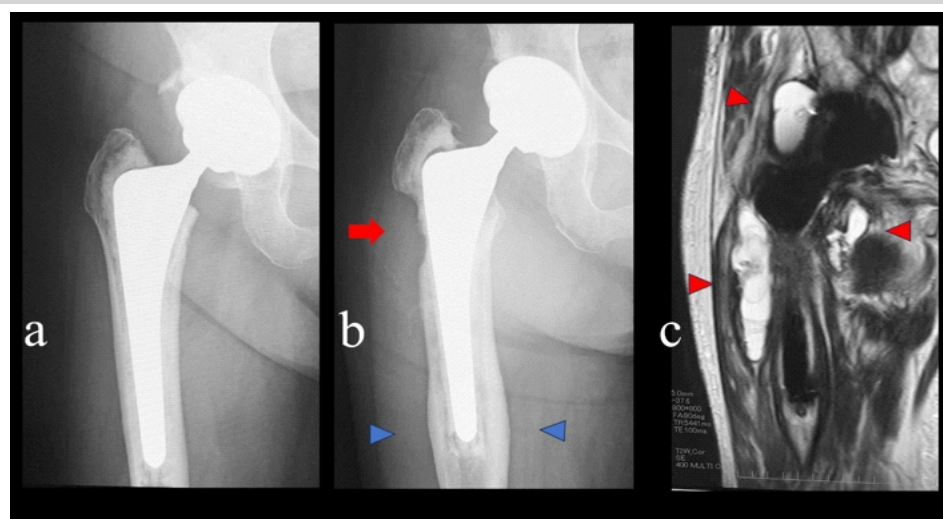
Reason for revision of total hip arthroplasty in Case 2. (a) X-ray after primary cemented total hip arthroplasty. (b) Three years post-operative X-ray showed bone resorption in the proximal lateral femur (red arrow) and cortical hypertrophy at the distal stem (blue arrowheads). (c) Magnetic resonance imaging T2-weighted coronal imaging revealed abscess formation around the prosthesis (red arrowhead).
